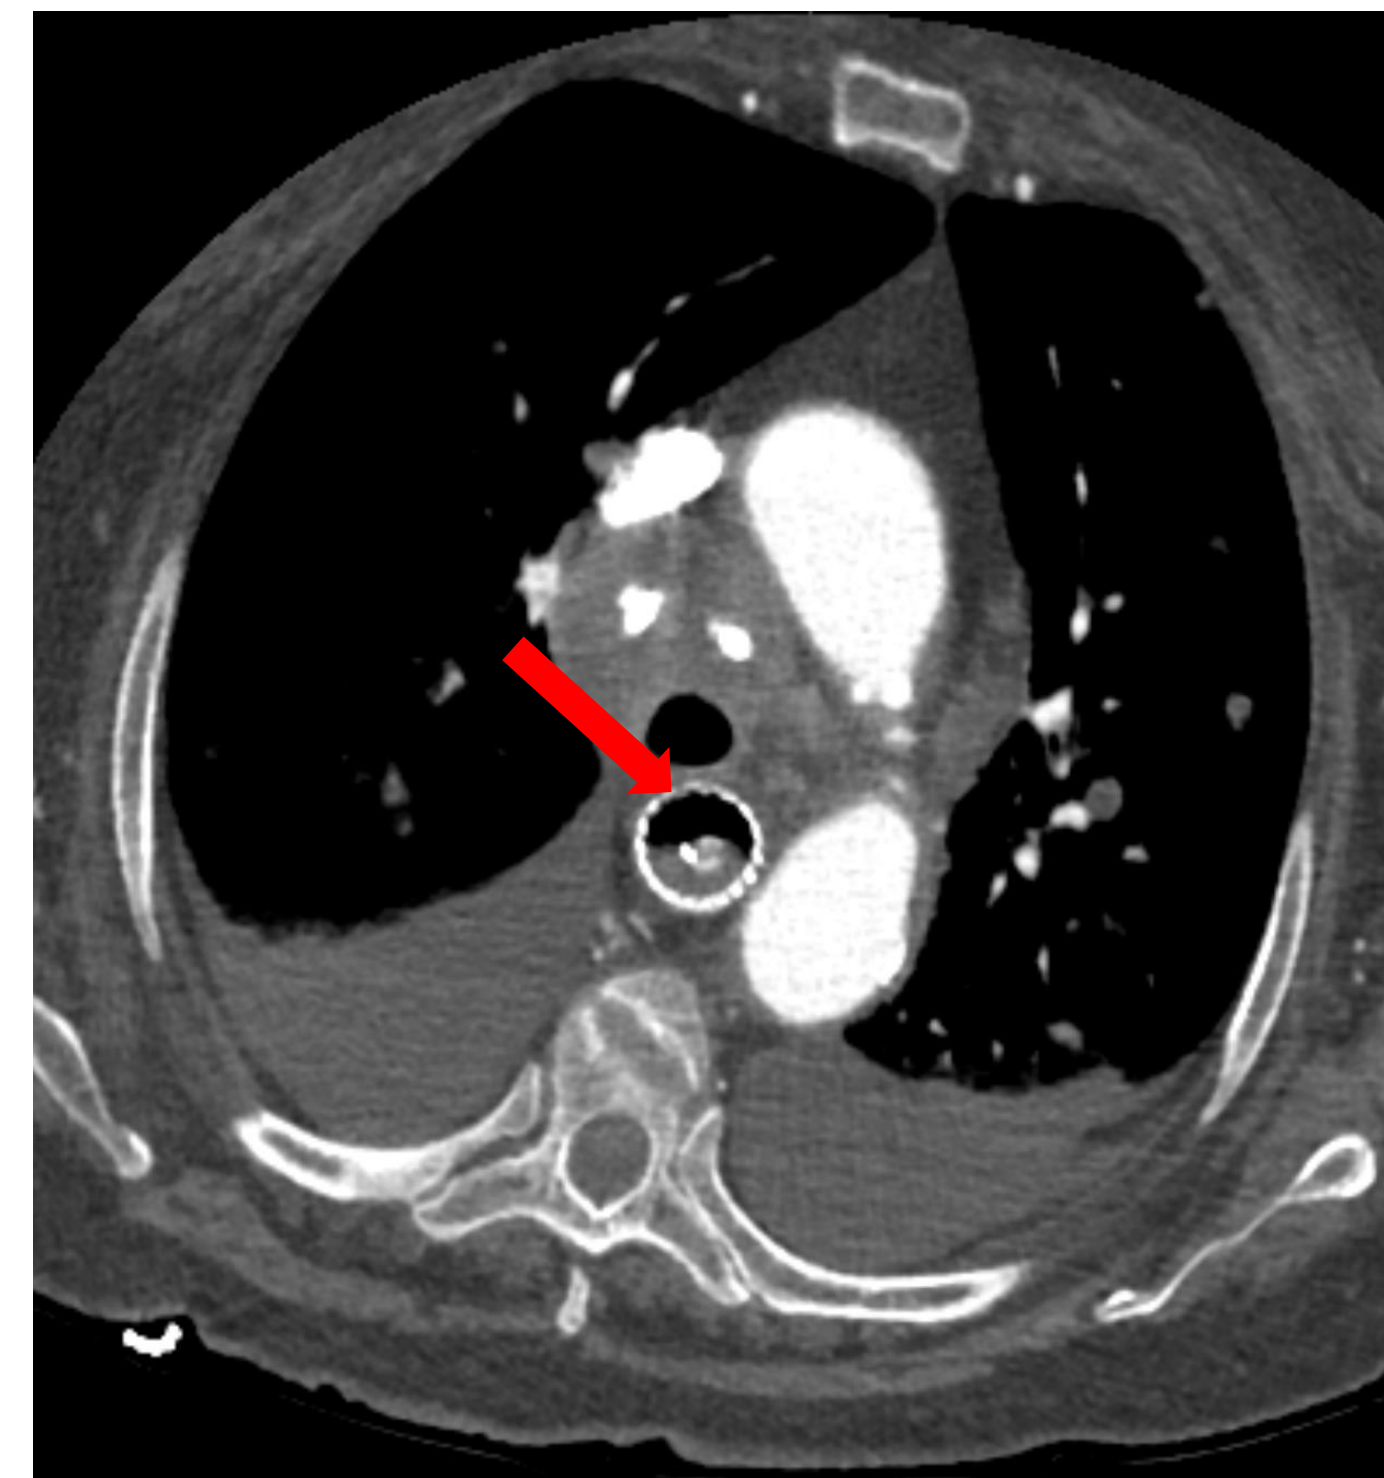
CT of the chest with contrast on axial section shows the esophageal stent placed across the tumor (red arrow)
